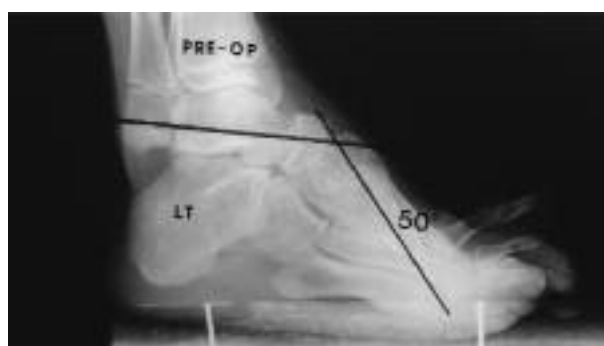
Preoperative lateral radiograph of a left calcaneocavus foot in a patient with sequelae from poliomyelitis.
